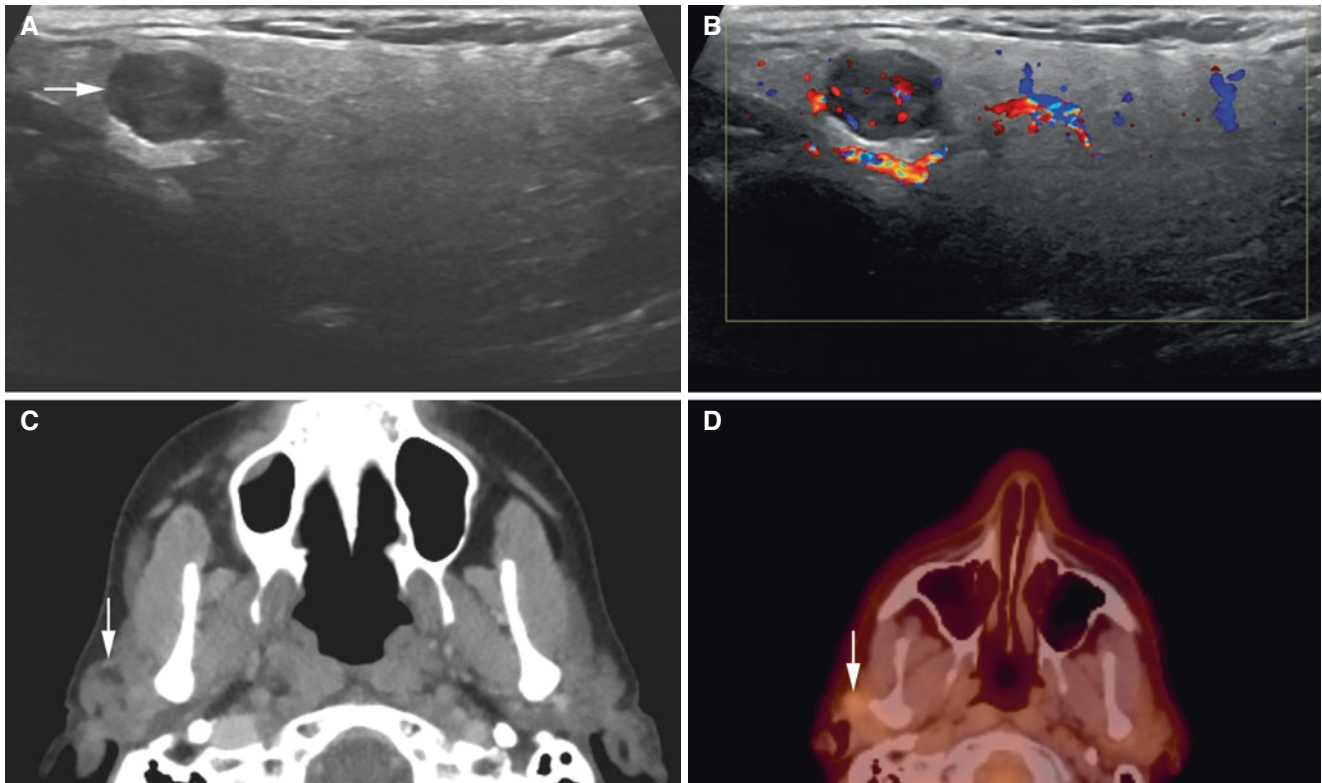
Parotid pleomorphic adenoma; 67-year-old male with pain-free small swelling of the right parotid gland. (A) US and (B) US (Doppler) show well-defined hypoechoic mass (arrow) and hyper-echoic, vascularized area. (C) Axial post-contrast CT image shows
